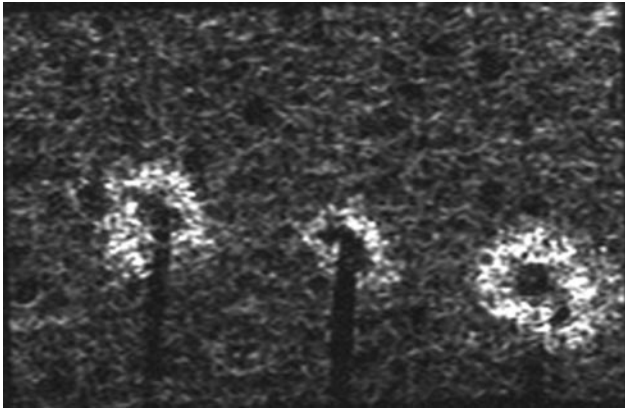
Magnetic resonance imaging (MRI) of a single slice of the sponge in Figure 4, obtained after 20 min of aerosol administration. The lack of greater signal intensity at the periphery of the region of interest, compared to the center, for each endotracheal tube, and lack of MRI signal connecting outputs of any 2 ventilators rules out substantial leakage of aerosol delivered from one ventilator to another at the ETT end.
